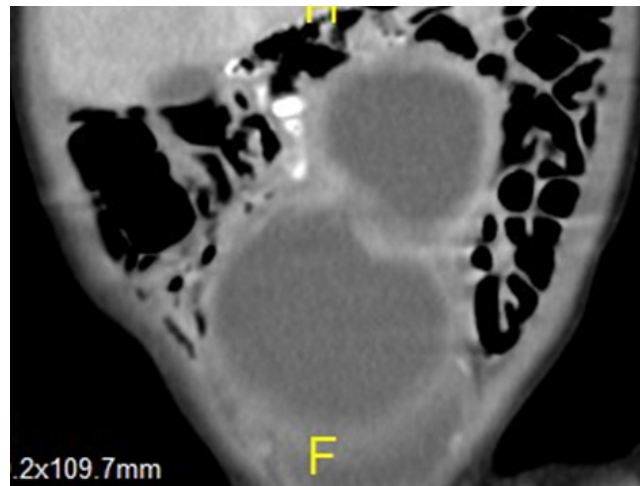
and 3B: CT-scan of the abdomen and pelvis showing hydrometrocolpos in a newborn with McKusick-Kaufman Syndrome. Note the large cystic mass in the first photograph representing the markedly distended vagina.
